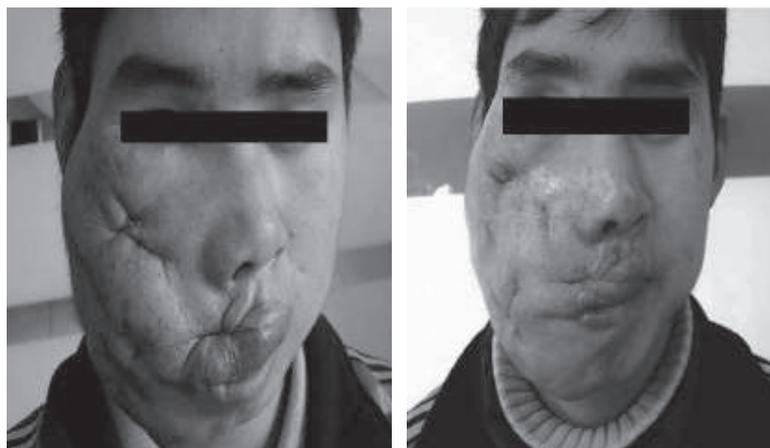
The same patient's appearance and MRI after EChT*
